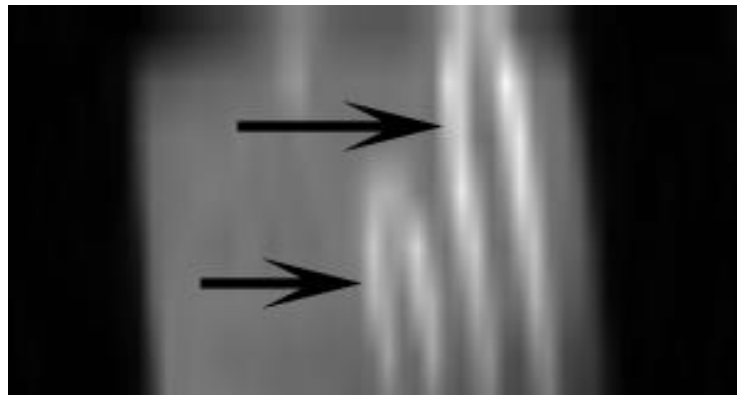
Maximum intensity projection of Magnevist® (25 μL contrast agent in 250 μL blood) infused clots suspended in saline utilizing T1-weighted imaging. Arrows point to clot sections.
